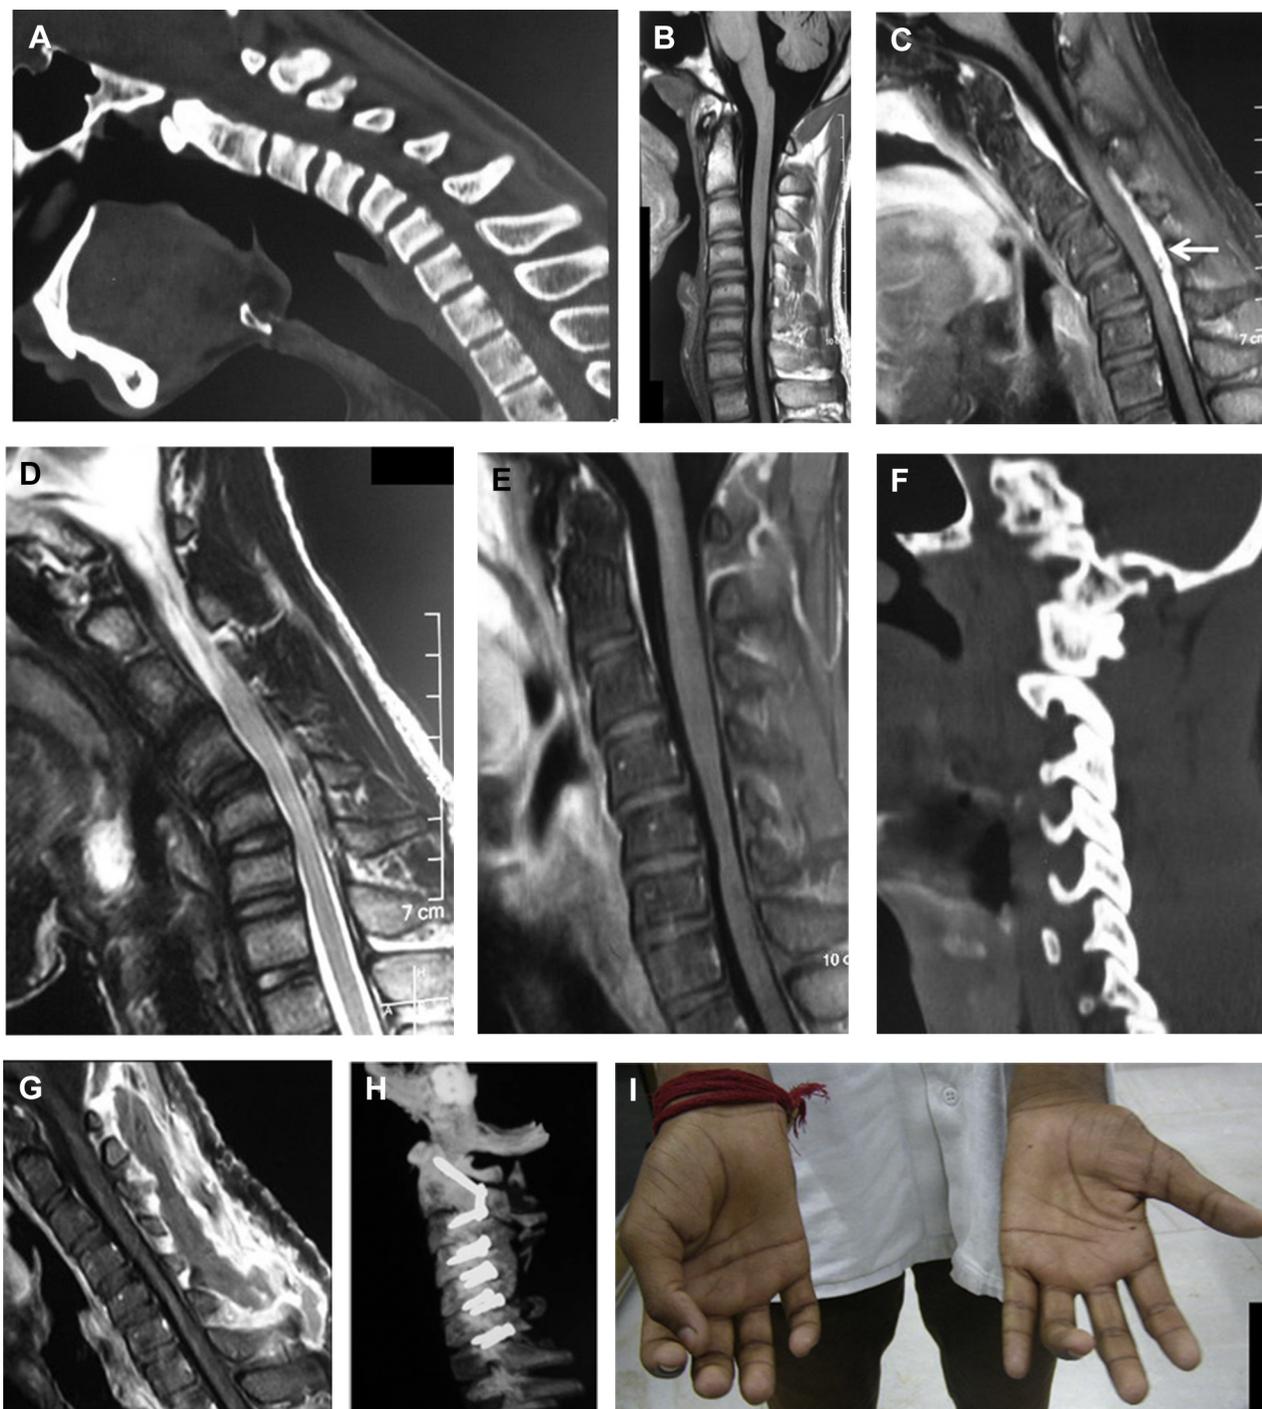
Images of a 16-year-old male patient. (A) Sagittal computed tomography (CT) scan shows hyperflexion of the neck. (B) T1-weighted magnetic resonance imaging (MRI) with the head in mild flexion shows ill-defined hypointense lesion posterior to the lower cervical cord. (C) Contrast-enhanced sagittal MRI with the head in flexion position. Extradural enhancing mass is seen posterior to the lower cervical spinal cord (*arrow*) and anterior to upper cervical spinal cord. (D) T2-weighted MRI image with the head in flexion shows the heterogeneous abnormal
